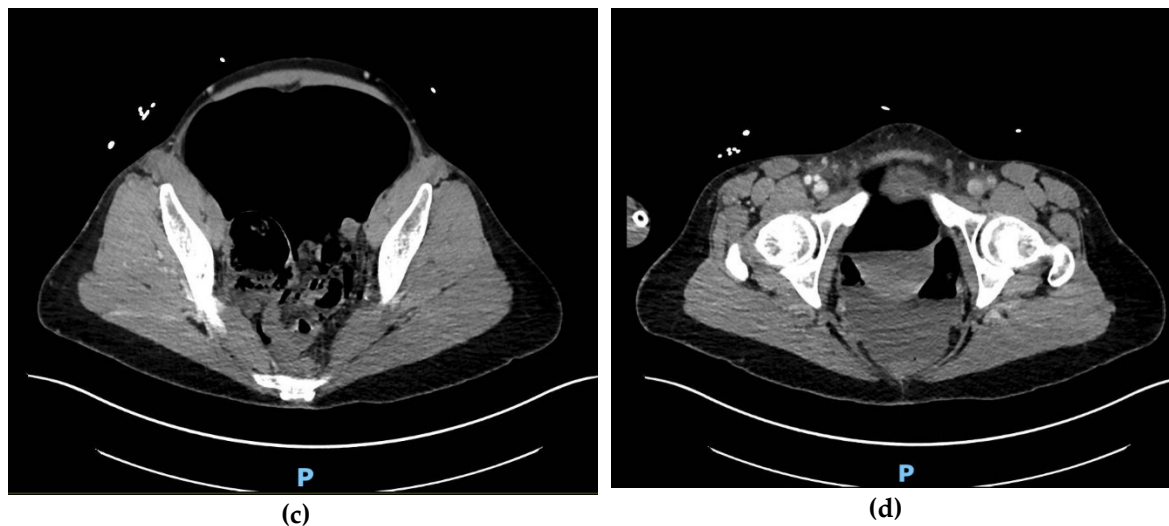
Computed tomography angiography taken in the emergency department of the patient's abdomen from superior (a) to inferior (d); (a) Diffuse wall thickening with pneumatosis of multiple small bowel loops; (b) Large volume pneumoperitoneum is shown to compress posterior structures, including abdominal aorta, via mass effect; (c) Pneumoperitoneum is shown occupy over half of the cross-sectional area of the abdominal cavity; (d) Mass effect from pneumoperitoneum is shown to compress organs all the way in the pelvis.
